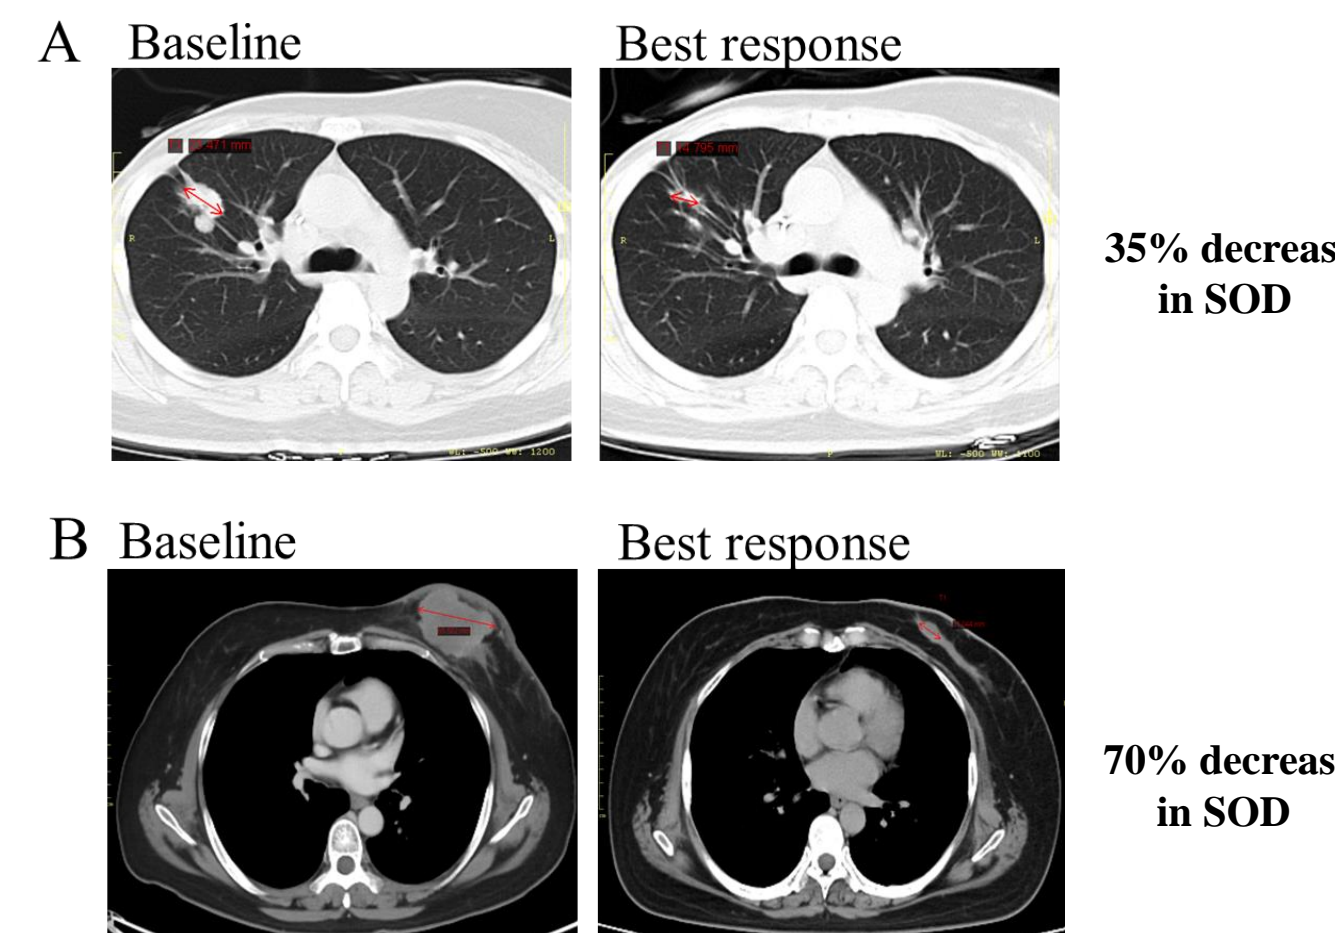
Representative CT Images of two BC subjects achieved a partial response (PR) with a best response of 35% (A) and nearly 70% (B) reduction in sum of diameters (SOD), respectively.
